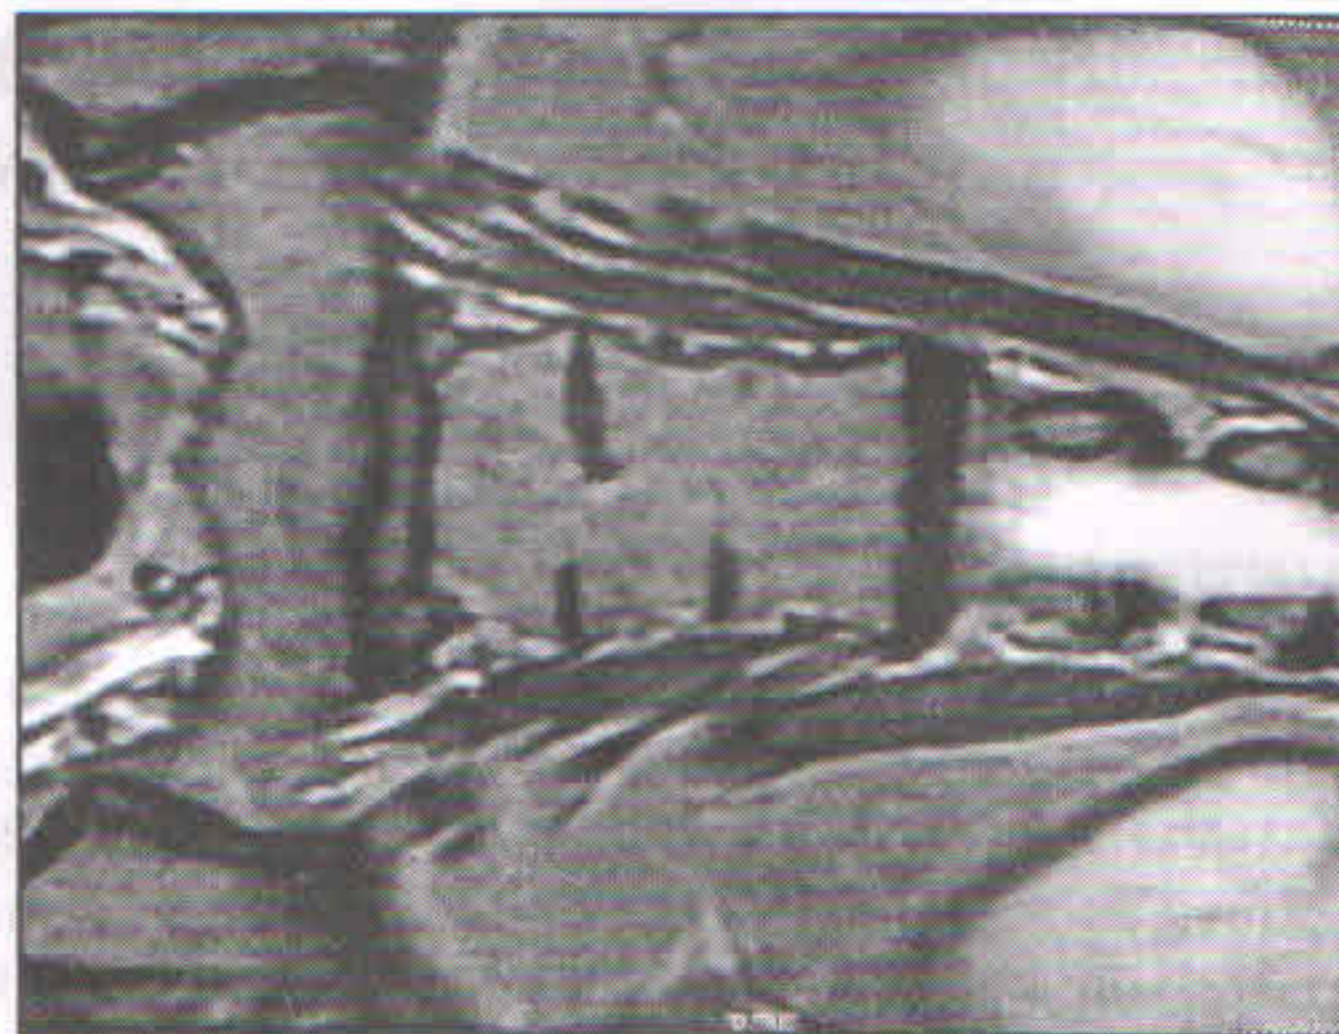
Sagittal and coronal MRI images of the lumbosacral spine showing L3-L4-L5 block vertebra, significant degenerative changes at L5/S1 disc and disc desiccation.
